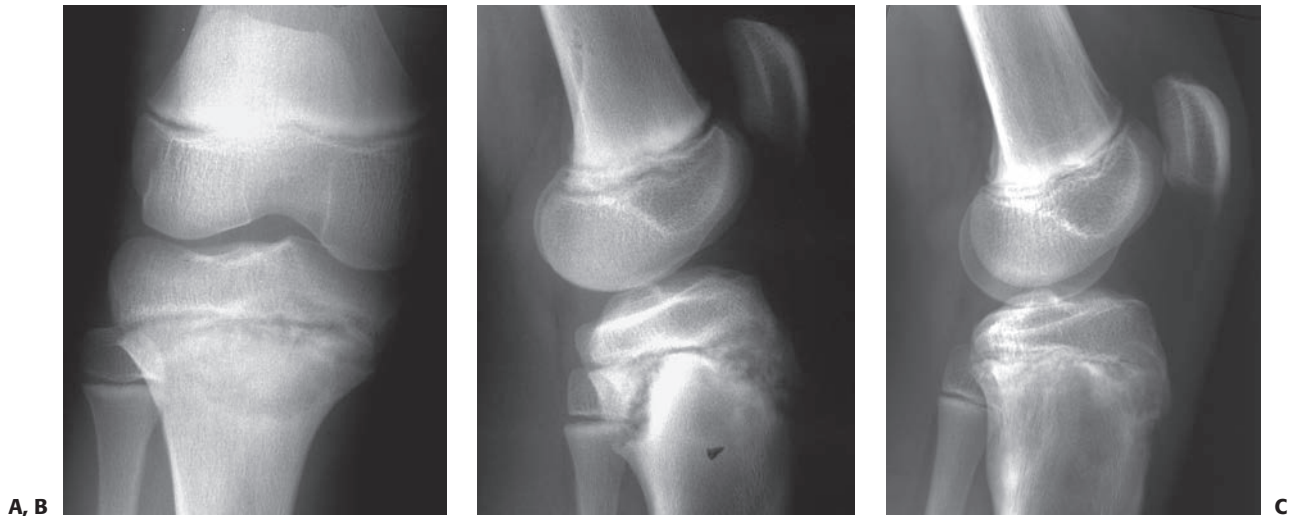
Stress injury of the proximal tibia in an elite soccer player. A: Anteroposterior radiograph film demonstrates subtle proximal tibial physal widening. B: Lateral radiograph shows widening, a metaphyseal Thurston-Holland fragment, and some posterior displacement of the proximal epiphysis. C: Significant radiograph improvement noted after discontinuing athletic activities for 3 months.
